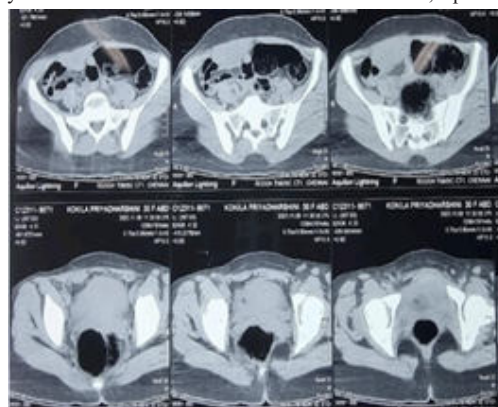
Contrast Enhanced CT Scan Showing Desmoid Tumour
